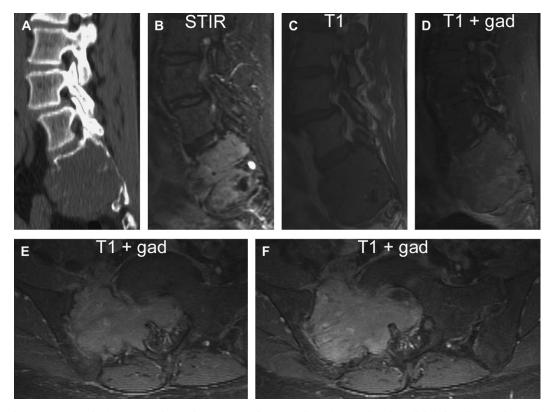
(A) CT sagittal reconstruction and (B–F) MRI demonstrating a large, enhancing, slightly hypointense destructive mass of the sacrum. gad, gadolinium; STIR, short TI inversion recovery. (Courtesy of J. Chi, MD, MPH, Baltimore, MD.)
